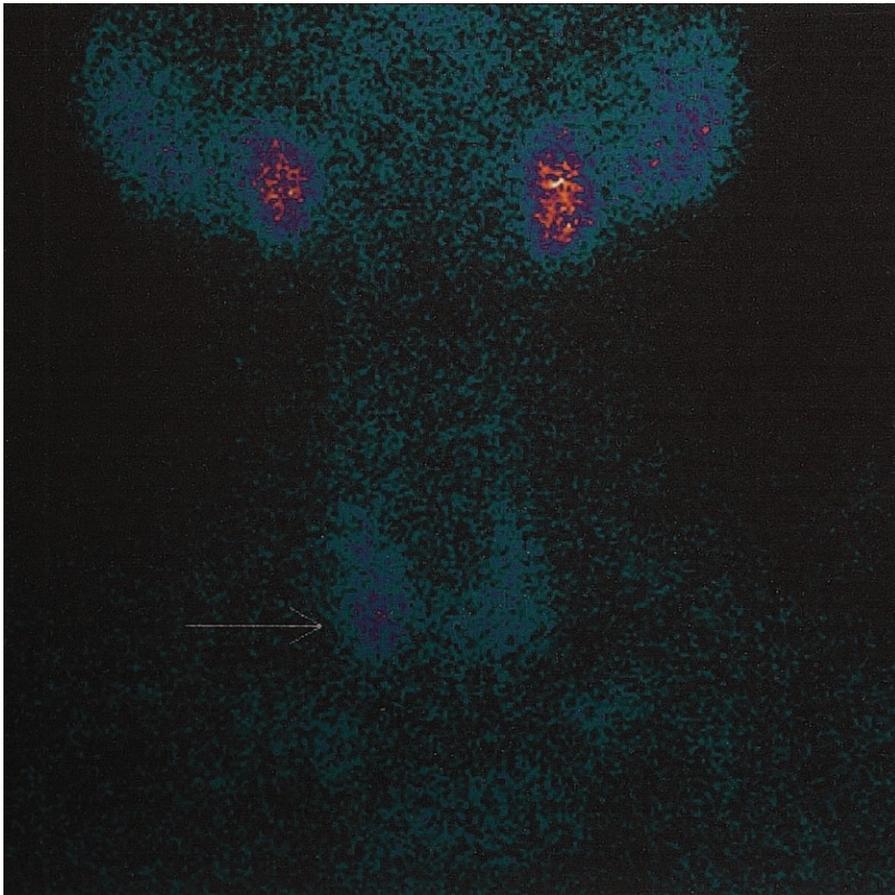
Preoperative parathyroid scintigraphy with late static images revealing remnant activity in the right inferior parathyroid gland.
